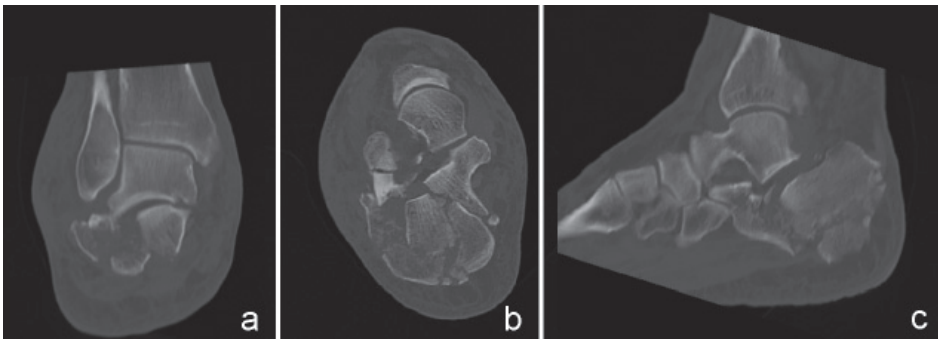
Example of a CT-image of a Sanders type IIB type intra-articular calcaneal fracture
